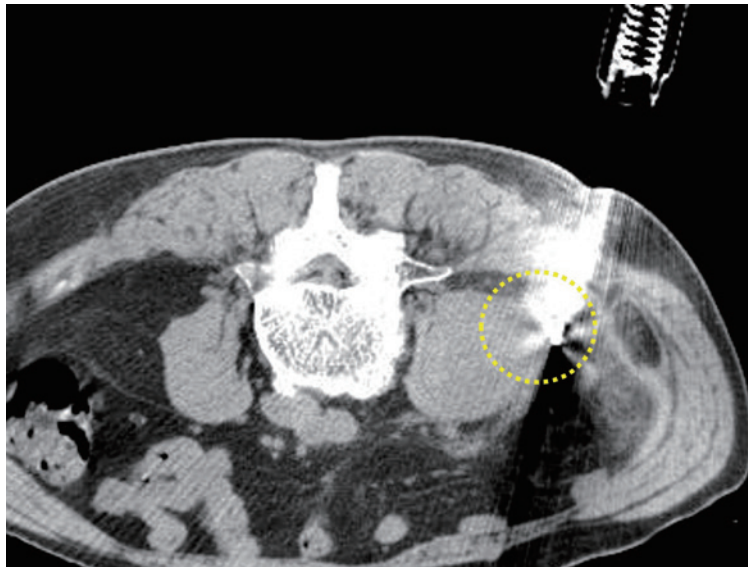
Aspiration sampling of material again and Core needle biopsy (yellow dotted circle) under real time US and CT guidance on the 11th hospital day
